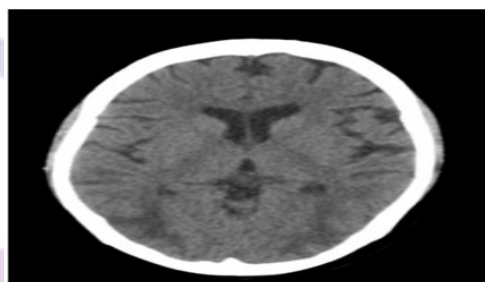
21 year old female with h/o postpartum eclampsia Non contrast CT reveals symmetrical areas of hypodensity noted involving bilateral parieto-occipital lobes-Suggestive of PRES.
